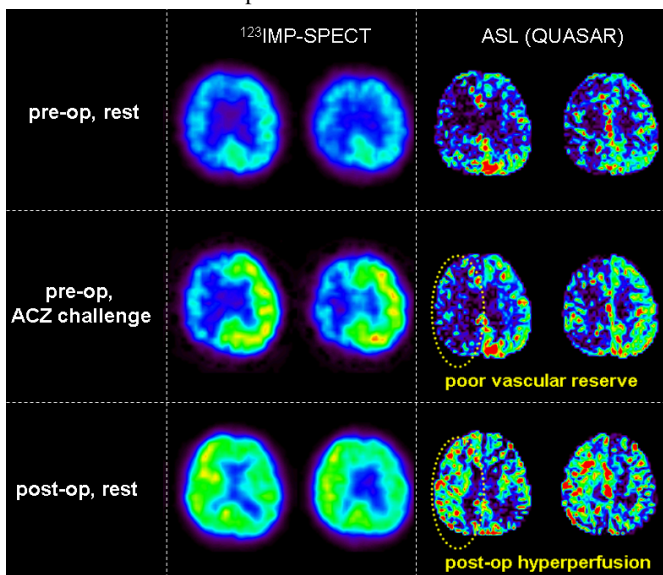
CBF maps of a patients with severe right ICA stenosis in different conditions. Both ASL and SPECT demonstrated preoperative poor cerebral perfusion, poor vascular reserve, and postoperative hyperperfusion phenomena in affected side.
